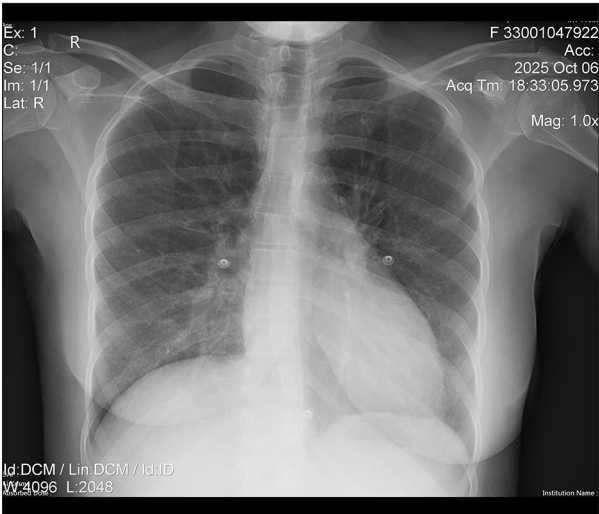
Anteroposterior chest radiograph. The image demonstrates well-aerated lungs without clinically significant loss of aeration. Structural findings include mild right basilar fibrotic changes, localized peribronchial thickening, and minimal pleural reaction. The hila appear prominent without focal abnormality, and the pulmonary vasculature is mildly prominent. The costophrenic angles and mediastinal contours are within normal limits.
